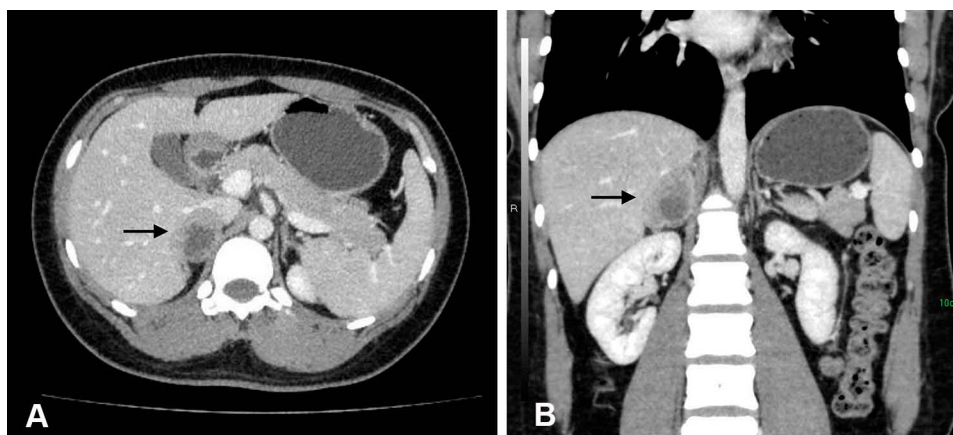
Preoperative abdominal contrast-enhanced CT scan showed a well-circumscribed heterogeneously mass in the right suprarenal areal (arrow). (A) Axial sections and (B) coronal sections.
